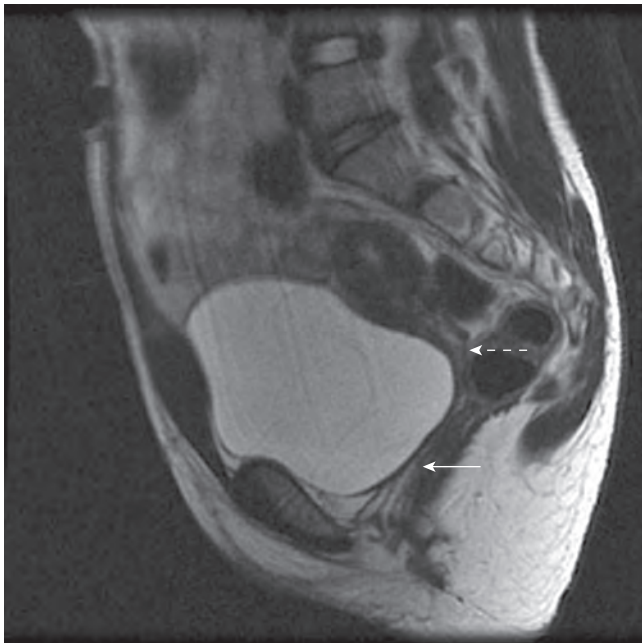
Magnetic resonance imaging scan of the pelvis in a 12-year-old girl with Klippel-Feil syndrome and associated proximal vaginal and cervical atresia. The *solid arrow* points to the most cranial portion of the perineal vaginal pit. The *dashed arrow* points to the most inferior aspect of the uterus, where no cervical impression can be appreciated.
